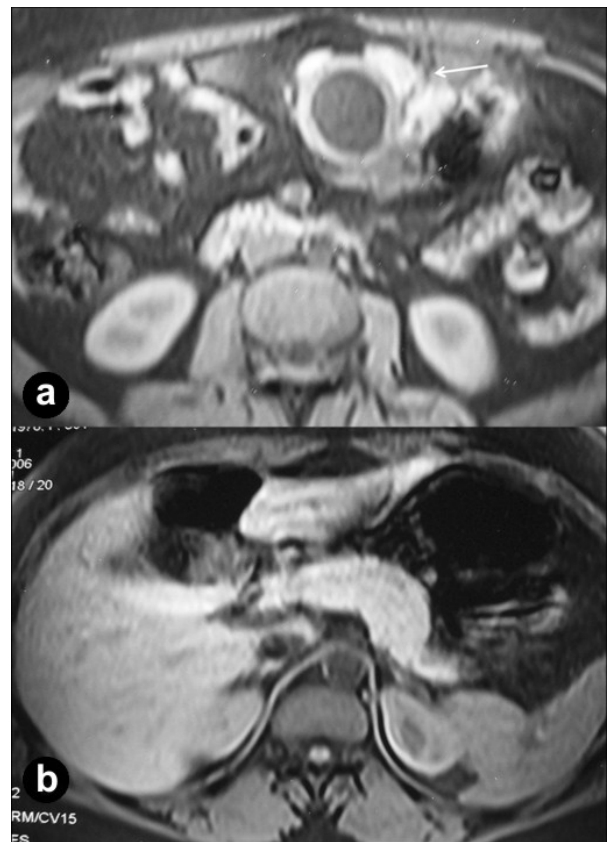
Contrast-enhanced CT (axial sections) of the abdomen showing a well-defined cystic lesion surrounded, on its anterior and lateral walls, by an enhancing soft tissue mass with stippled fat density areas within (arrow), similar to pancreatic tissue. The cyst wall has a two layered appearance, with an inner thin hypodense layer and an outer enhancing layer.
